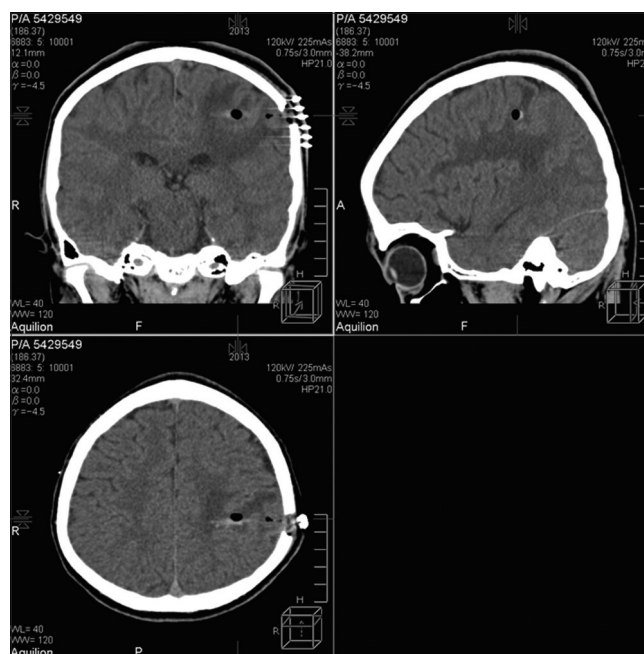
Postoperative computed tomography scan showing the burr hole and the needle track hitting the lesion
